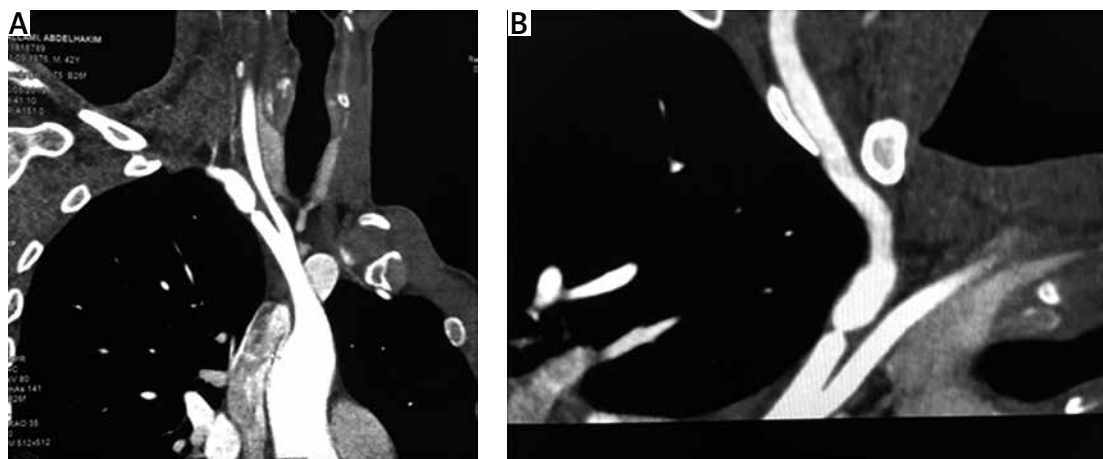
Thoracic angio-CT showing right subclavian artery stenoses.
